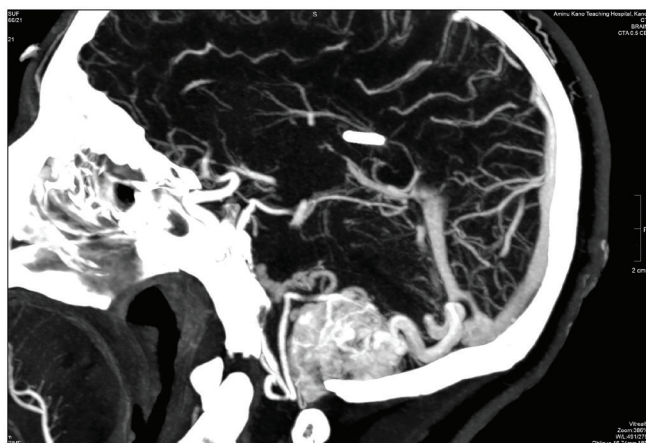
Sagittal reconstructed CTA of the posterior fossa, showing hypervascular mass with a feeding artery from the posterior-inferior cerebellar artery. Note the early venous opacification, suggestive of an AV malformation
